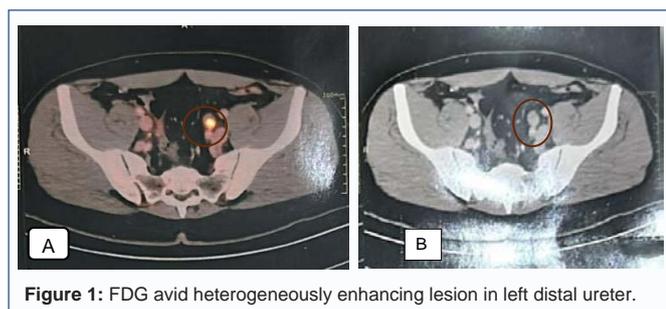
FDG avid heterogeneously enhancing lesion in left distal ureter.
